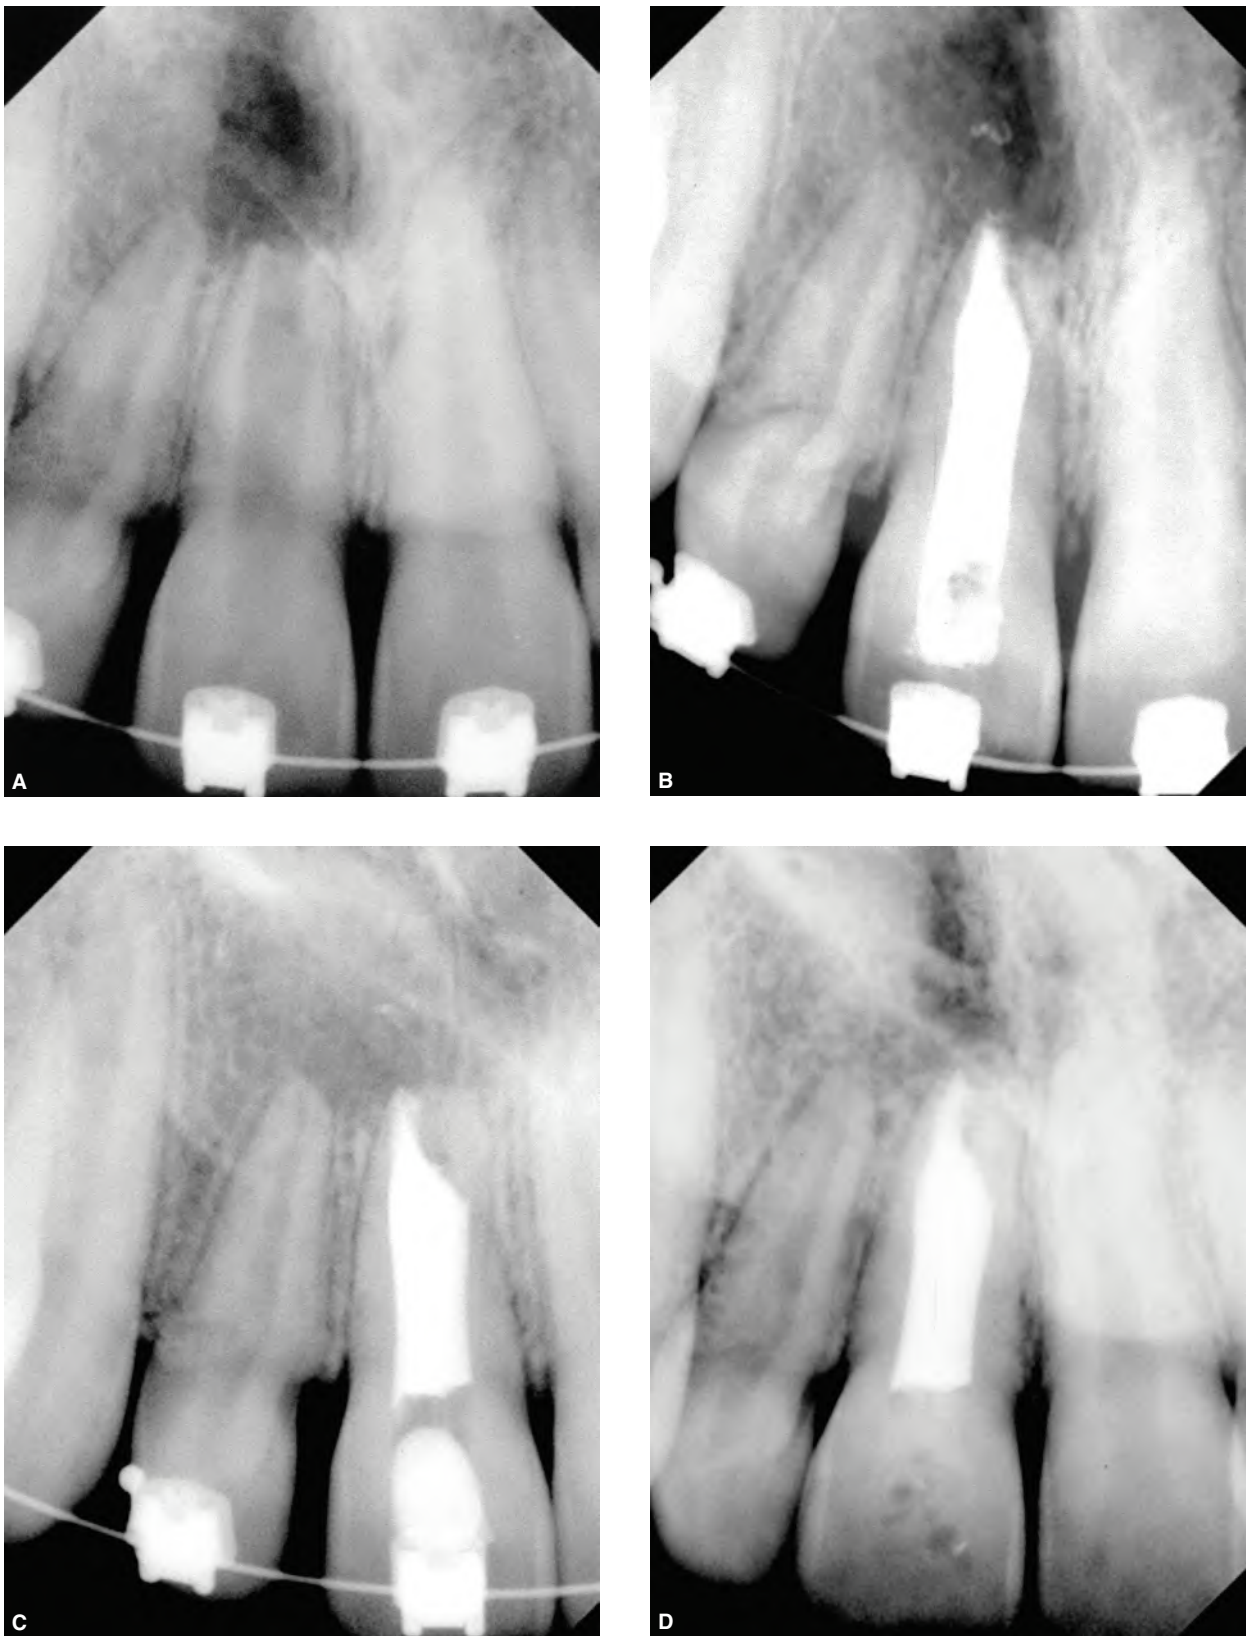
A. Radiograph of a maxillary right central incisor taken after OTM has begun. The 18-year-old female patient had suffered trauma at an earlier age, however no periapical radiograph was taken prior to OTM nor were the teeth tested. B. The tooth was accessed (pulp was necrotic), the canal shaped, cleaned and disinfected and filled entirely with MTA. Note, there was only a small opening apically, even though the original radiograph depicted immature root development. C. Six-month evaluation showing some osseous repair. D. Eighteen-month evaluation showing good healing. The patient is symptom-free.
